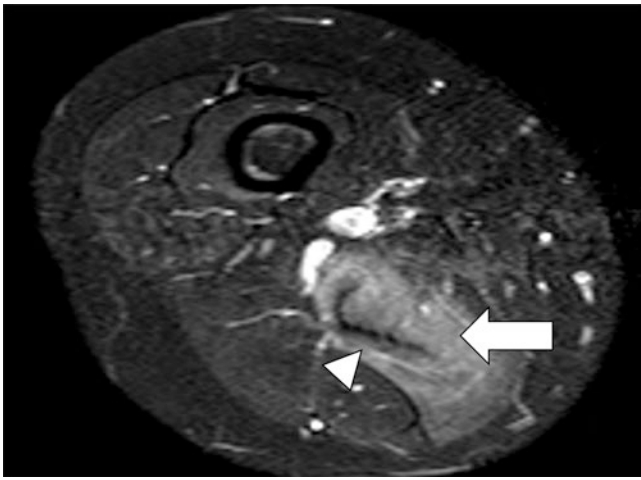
Fat-saturated STIR MR image of the right thigh in a patient with known Sjogren's disease and polymyositis demonstrates marked diffuse edema isolated to the semimembranosus muscle (white arrow). Notice the diffuse endomyosial pattern of muscle involvement with sparing of the fascia and myotendinous junction (white arrowhead)
